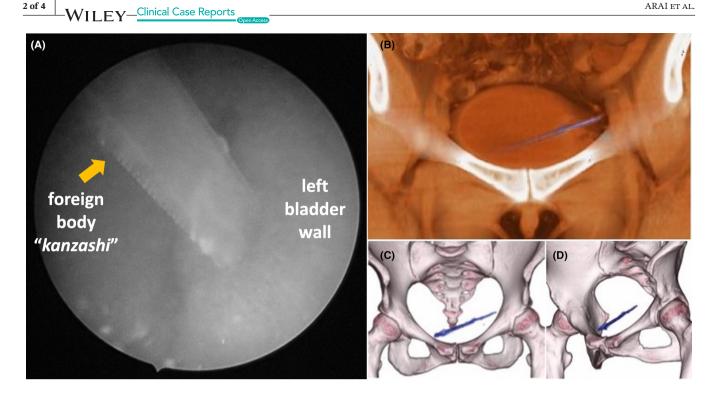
(A) Cystoscopic image. A foreign body was stuck into the left bladder wall. It is displayed in grayscale at the patient's request. (B) A coronal section image of computed tomography (CT). A foreign body penetrates the bladder wall. Soft tissues are colored vermilion and foreign body in blue for easy identification. (C, D) Front and left oblique view of pelvic three-dimensional reconstruction CT, with a foreign body colored blue for easy identification. A foreign body is colored blue for easy identification.
